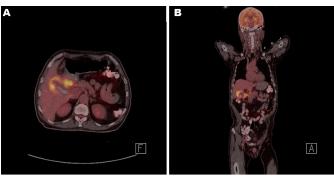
(A, B) PET-CT scan showing hyper metabolic activity around the gallbladder suggesting neoplasm.
